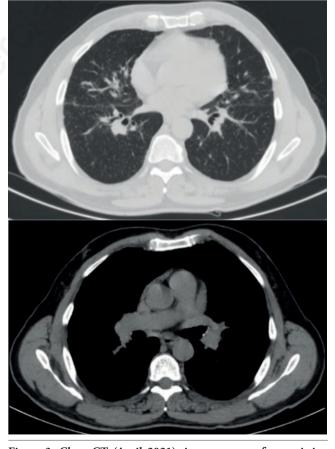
Chest CT (April 2021): improvement of pre-existing changes in lung parenchyma, resolution of the micronodular pattern of perilymphatic and perisural distribution; dimensional reduction of bilateral mediastinal and hilaradenopathies.
